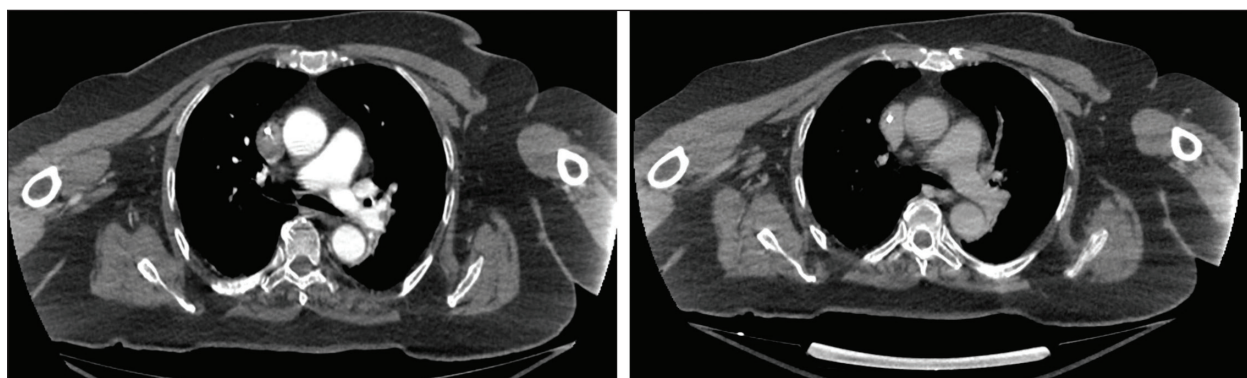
48-hour postprocedure CTA showing resolution of thrombus.
